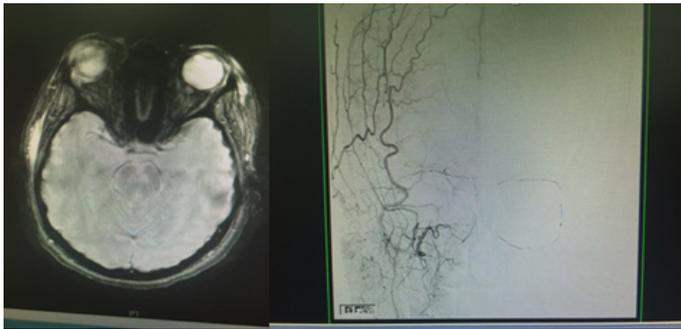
Infarction of the right optic nerve Absence of right retinal vascular blush (MRI) (Right carotid angiogram).
